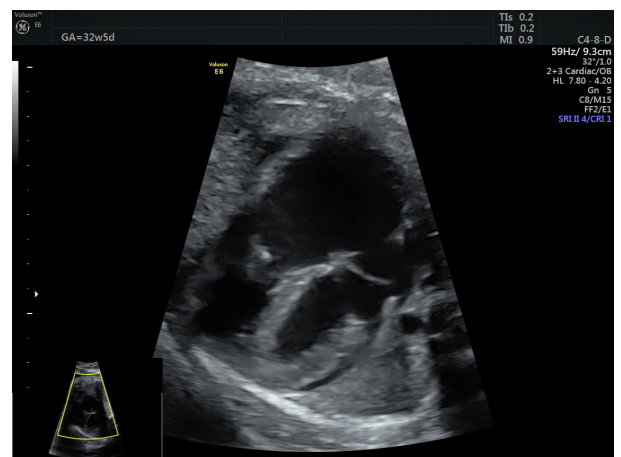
Fetal echocardiogram four-chamber image in a 32-week gestation fetus with Ebstein's anomaly
